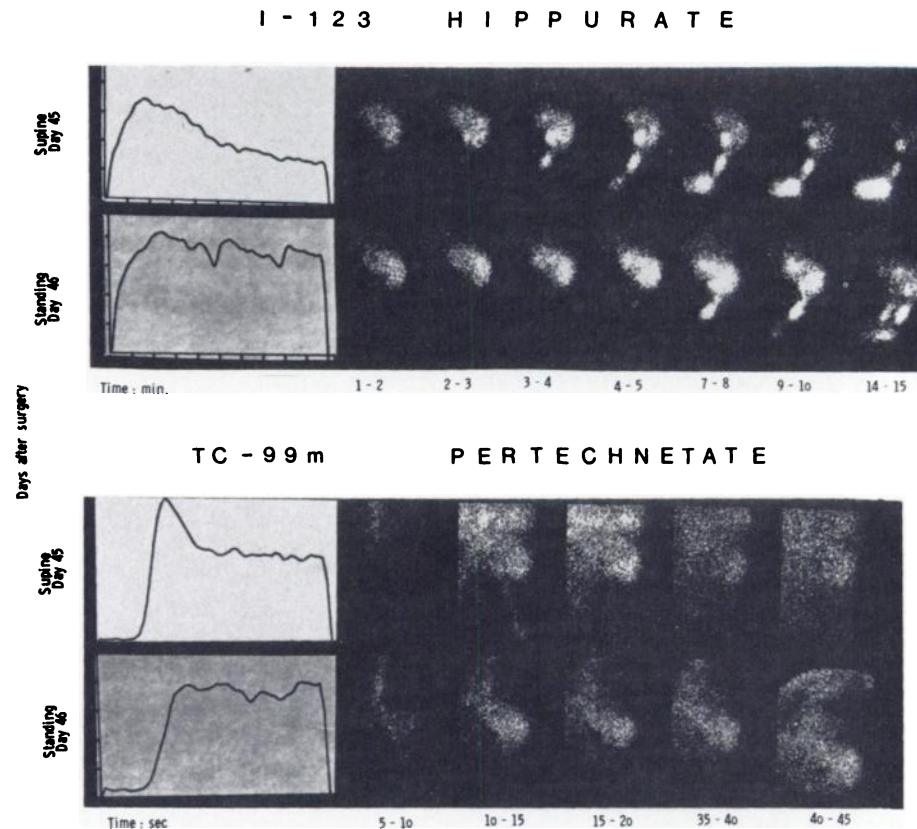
Iodohippurate renography and pertechnetate perfusion scintigraphy in hypertensive patient (No. 6), examined in supine and standing positions on Days 45 and 46 after graft implantation. Biochemical data were stable at time of examinations. Change from supine to standing position disturbed intrarenal transport, delayed bladder appearance time, and markedly altered pertechnetate flow pattern.
